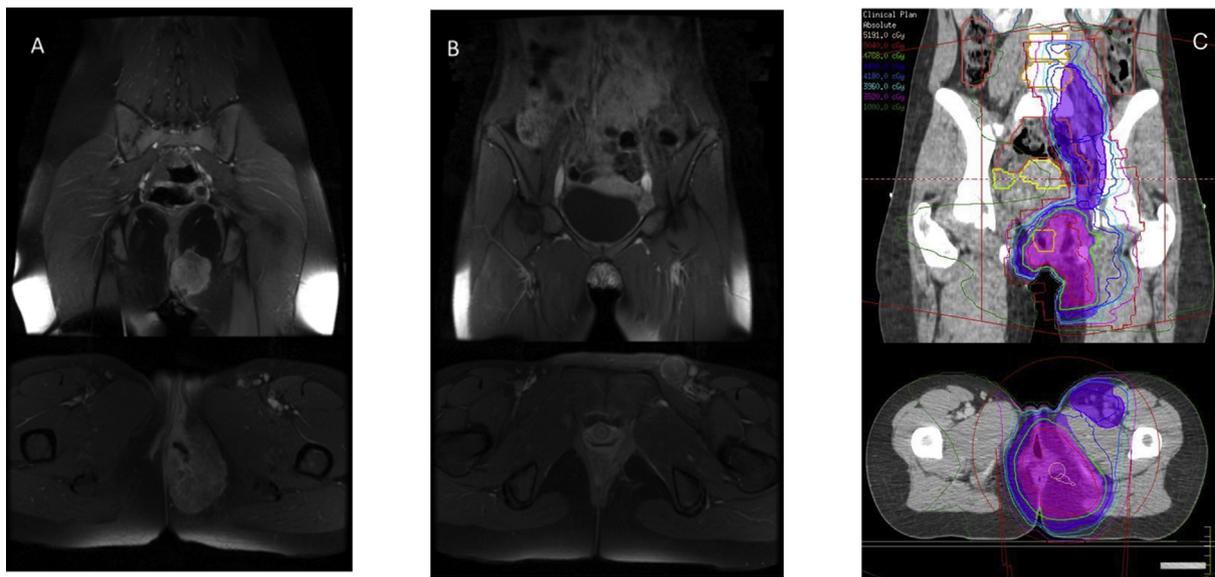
Rotational intensity-modulated radiotherapy using a simultaneous integrated boost technique for perineal alveolar rhabdomyosarcoma. (A) Coronal and axial T1w + c magnetic resonance imaging (MRI) showing perineal primary tumour; (B) coronal and axial T1w + c MRI showing left external iliac and left inguinal lymphadenopathy; (C) coronal and axial images from single 6 MV Volumetric Modulated Arc Therapy (VMAT) arc plan, delivering 50.4 Gy (1.8 Gy per fraction) to the perineal primary and 44 Gy (1.57 Gy per fraction) to involved lymph nodes, both in 28 daily fractions.
